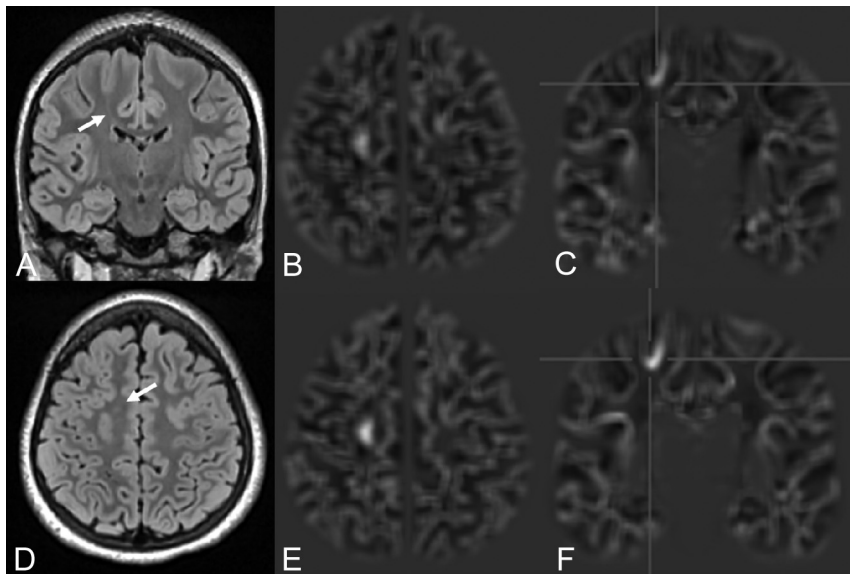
FCD with a transmantle sign of the right superior frontal gyrus (bottom-of-sulcus dysplasia) (FLAIR A and D) in an 11-year-old girl with left upper and lower limb somatosensory aura and motor seizures (patient 20). The MPRAGE- (B and C) and MP2RAGE-based junction images (E and F) match the signal abnormalities at the gray matter junction as a characteristic feature of FCD type II. MP2RAGE delivers, in this case, higher contrast junction images and better lesion definition compared with MPRAGE.
